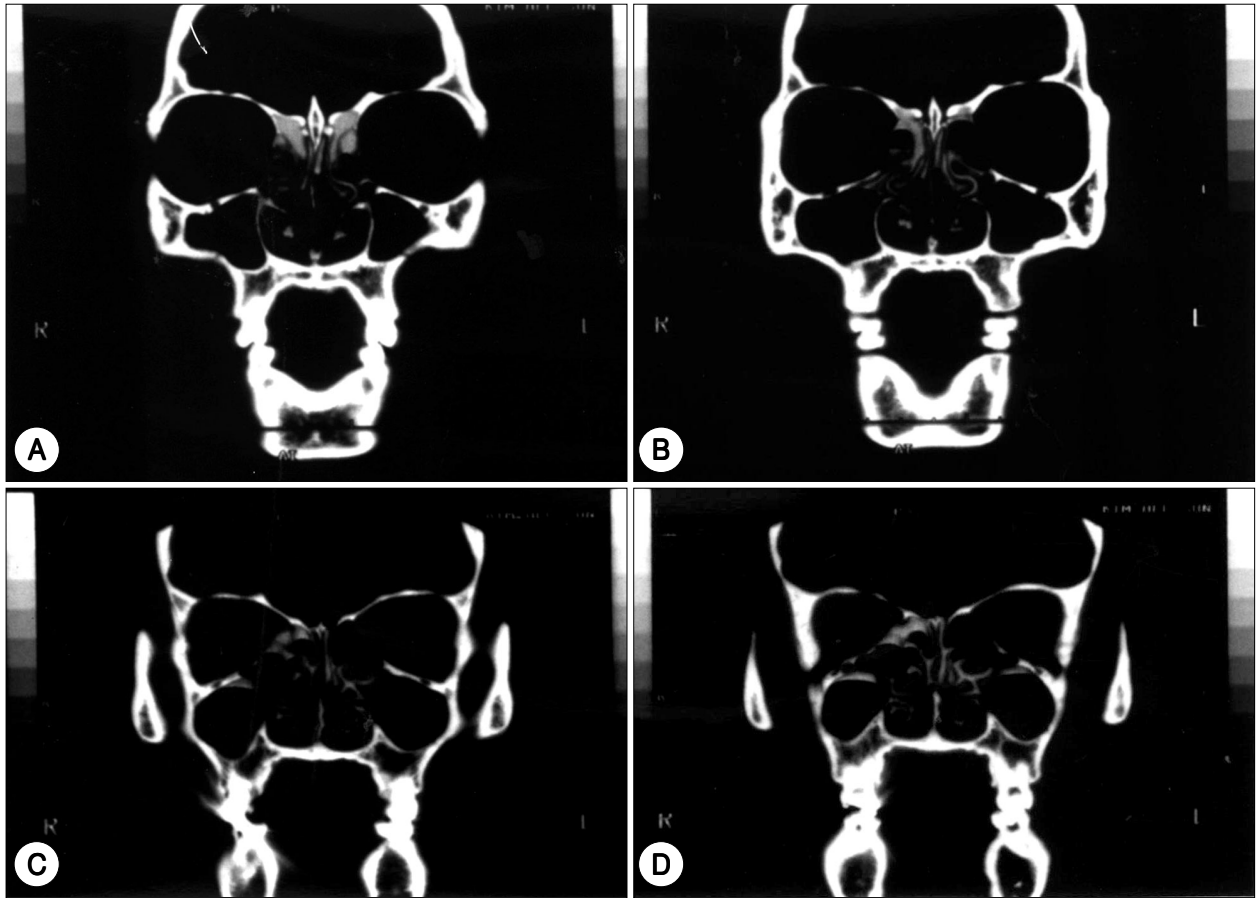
Contrast filled paranasal computed tomography demonstrating well visualized contrast around the olfactory cleft indicating good aerodynamic patency of nasal cavity.
